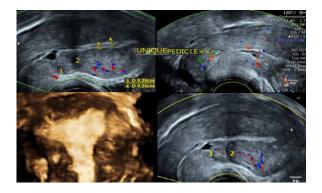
Transvaginal Ultrasound. 1: distal isthmocele; 2 proximal uterine scar; 3,4: measurements of the irregularly thick endometrial stripe; Yellow arrow: single endocervical vascular pedicle; 3D coronal plane of the uterus: adenomyosis.
